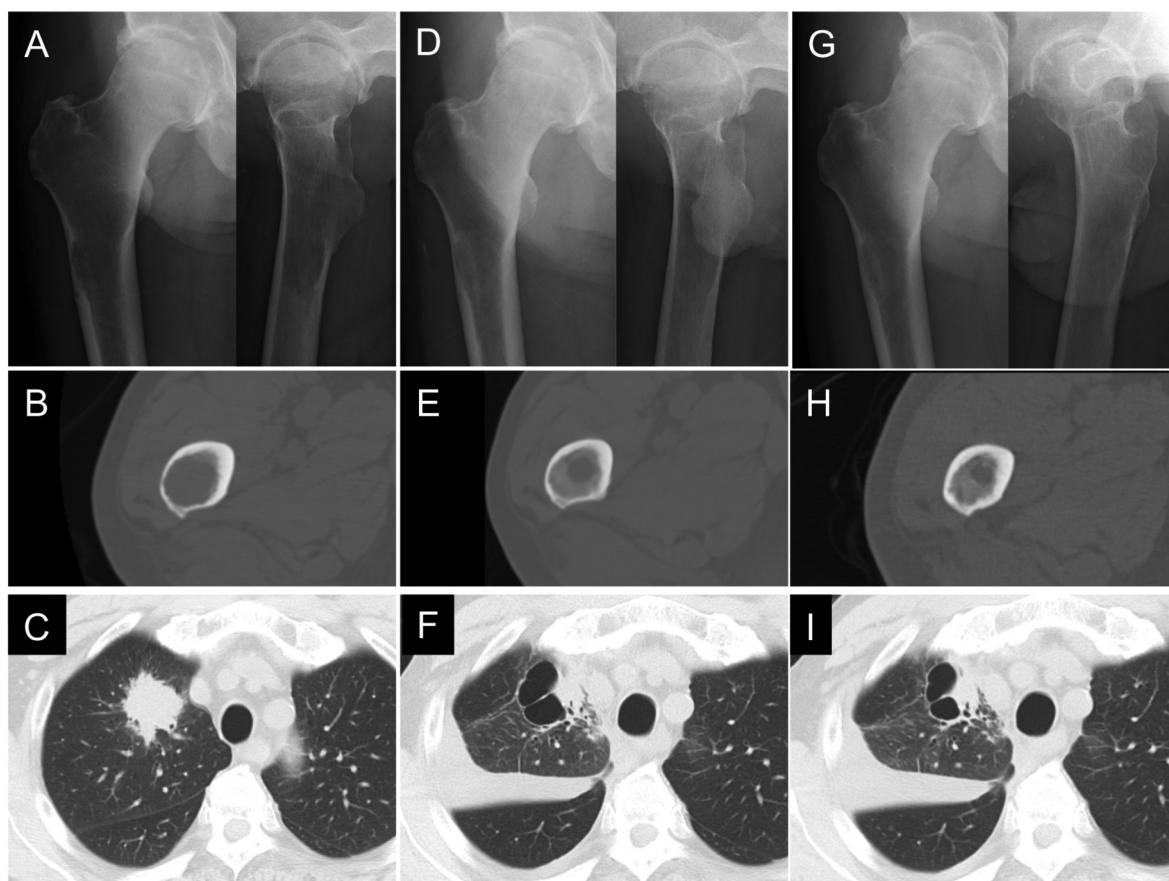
Case 2: X-Ray of a 71-year-old man with right thigh pain but no past medical history showed a radiolucent lesion on the right proximal femur (A). Computed tomography (CT) showed a metastatic lesion in the medullary cavity and a thinning of cortical bone (B). CT of the chest revealed a lung tumor (C). Three months after initiating pembrolizumab, X-ray and CT showed a remarkable osteosclerotic change in the bone metastatic lesion (D, E) and CT showed shrinkage of the lung tumor and residual pleural effusion (F). After 8 months of pembrolizumab therapy, X-ray and CT revealed repair of the bony metastasis (G, H), and CT showed that the shrinkage of the lung tumor had been maintained (I).
